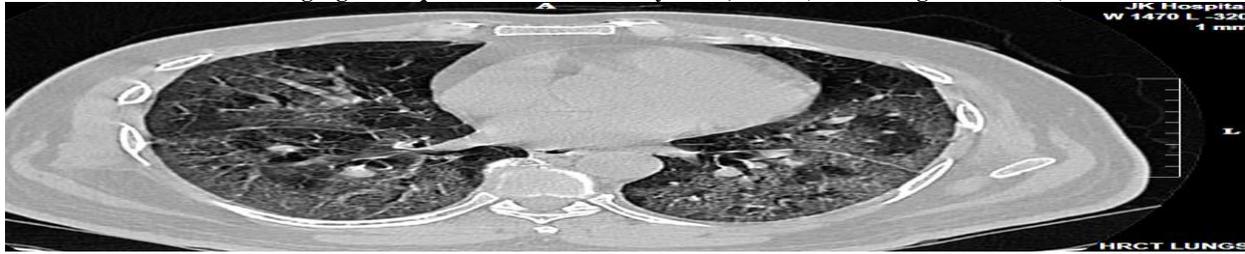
HRCT of Non co-morbid patient (HTN with CAD) showing multiple confluent patches of GGO and consolidation with interstitial septal thickening giving crazy paving appearance. CT severity score; 34-35 (Severe lung involvement).
